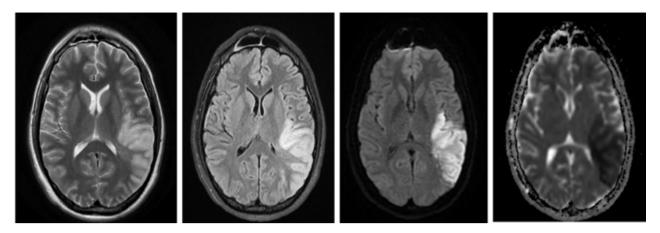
33-year-old gentleman with right-sided hemiparesis, MRI showing focus of diffusion restriction in left parietal region (arrow, bright on DW and dark on ADC with increased signal of T2W FLAIR).
